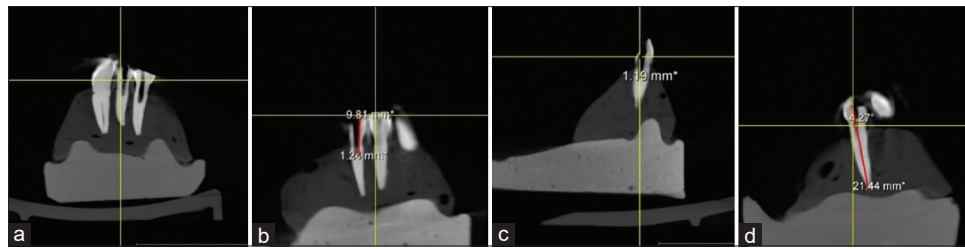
(a) Postoperative cone-beam computed tomography scan, (b) Tooth volume loss in coronal - apical and mesial-distal direction, (c) Tooth volume loss in buccal - lingual direction, (d) Angle deviation
